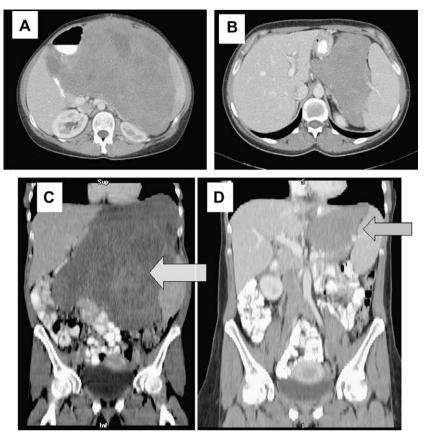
Response to liposomal doxorubicin. CT scan before (A, C) and after (B, D) nine cycles of liposomal doxorubicin for the treatment of a large localised sporadic desmoid tumour in a 31-year-old woman.
